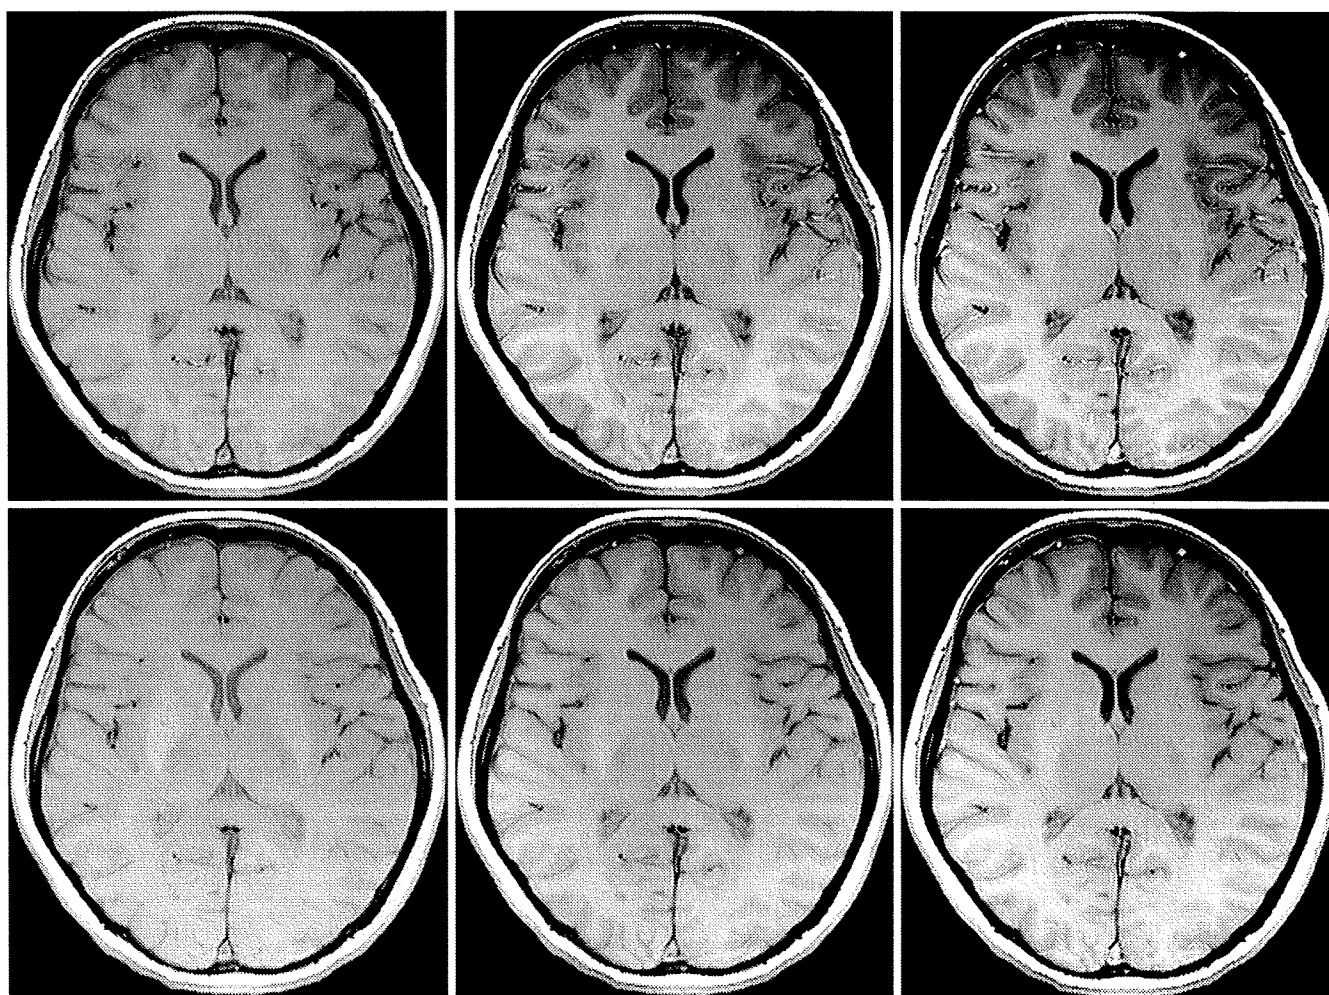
Spin-echo T1-weighted gapless multi-slice imaging without presaturation pulse (PP) (*upper row*) and with PP (*lower row*) at the level of the basal ganglia. From left to right, sequential imaging, 100% interleaved imaging, and 200% interleaved imaging are displayed. Gray matter and white matter contrast was more conspicuous with either 100% or 200% interleaved imaging than with sequential imaging.
